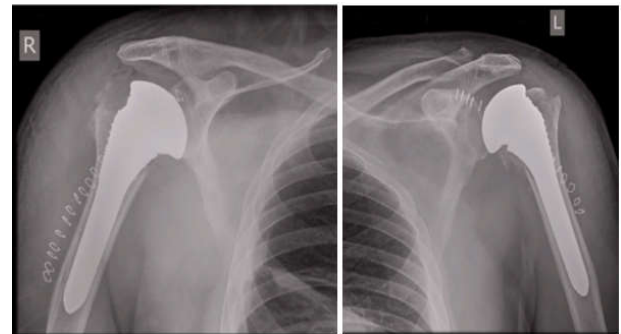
Post op xrays showing bilateral shoulder hemiarthroplasty
